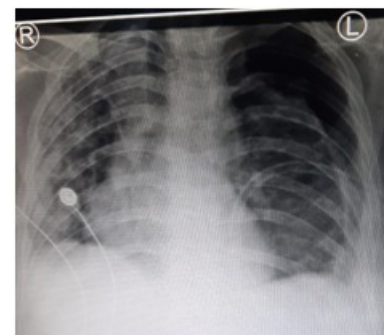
Chest X-ray, after tube pneumothorax thorakostomy was performed
